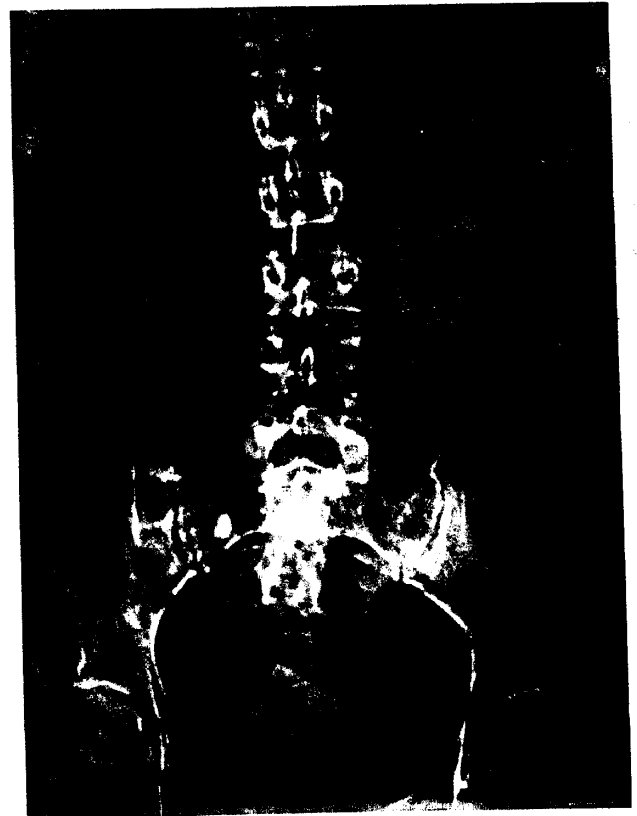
A: a plain radiograph, showing a calculus in the retained right ureteric stump; B: an enlarged view of the same ureteric calculus.
